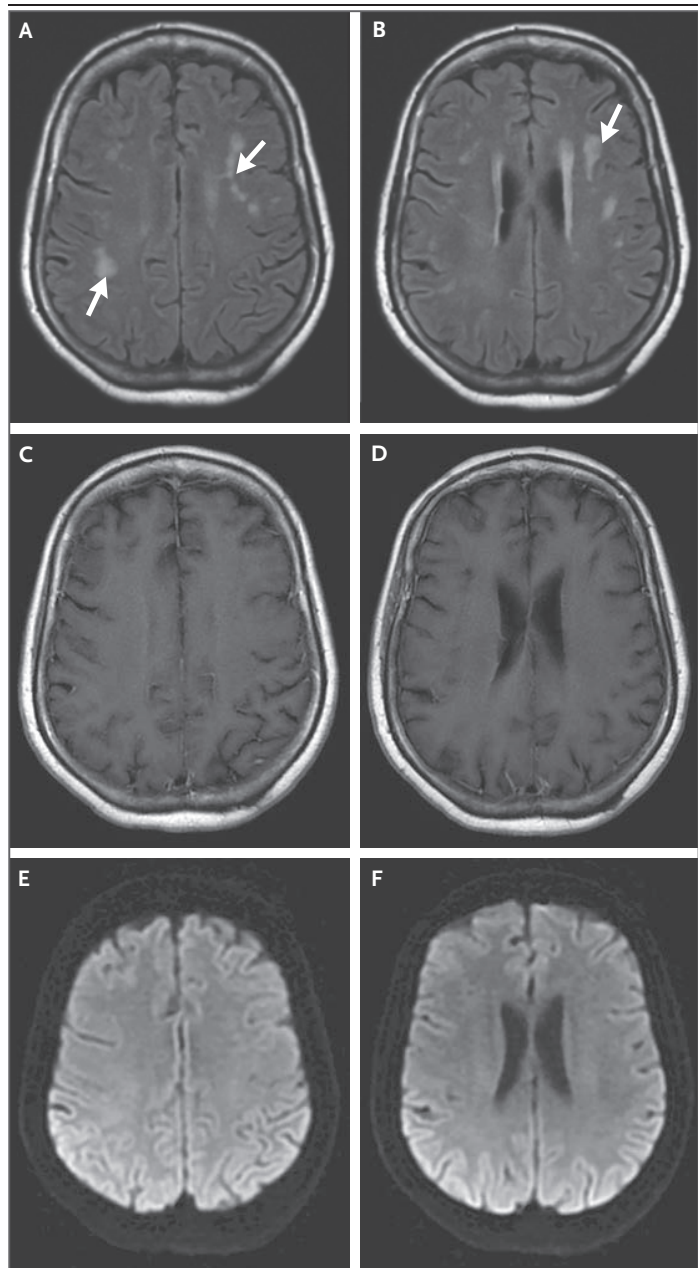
MRI of the Head.
